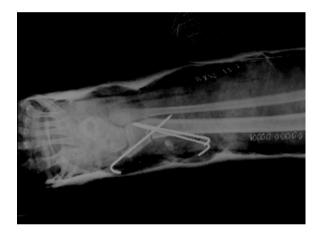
Postop tibial osteotomy X-ray.
